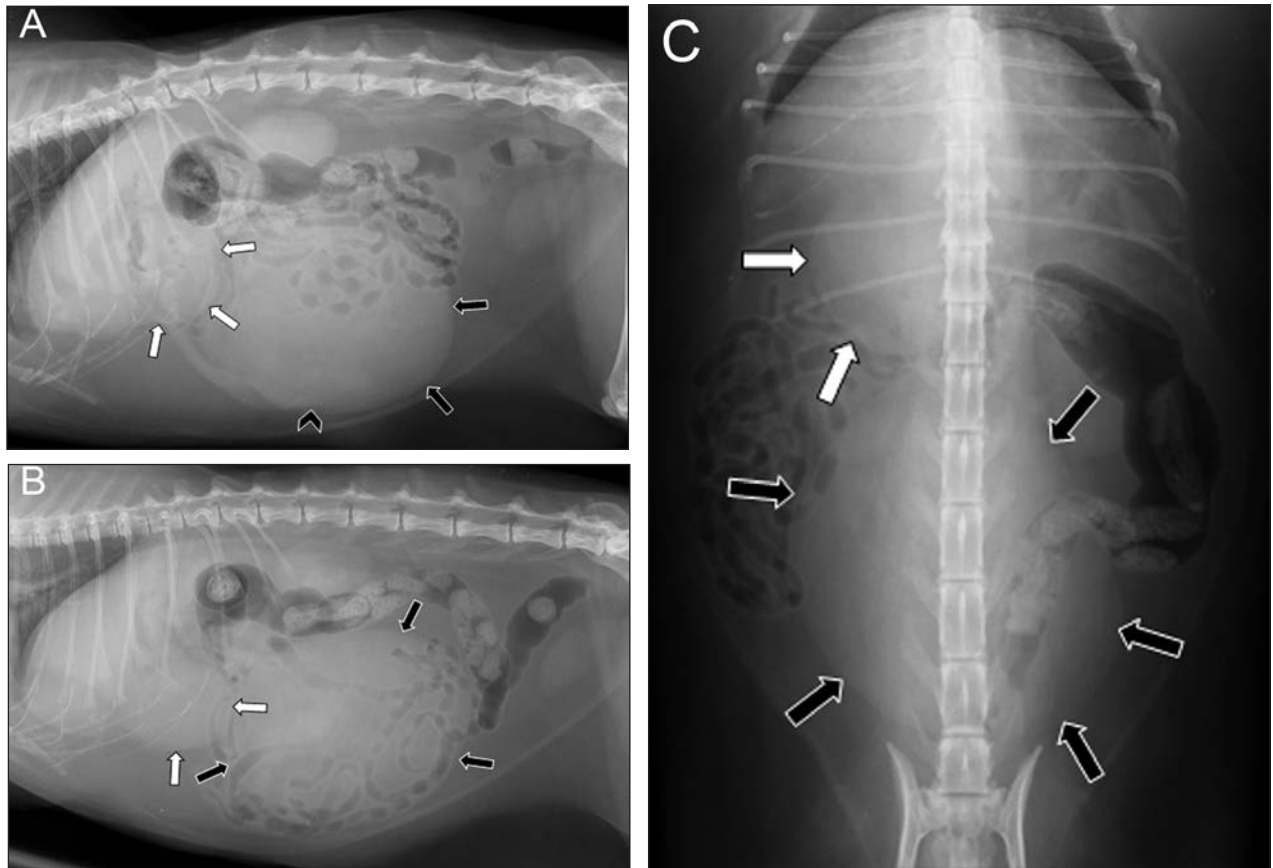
Same radiographic images as in Figure 1. There is a large midabdominal mass (black arrows). The border of the mass effaces with the tail of the spleen (black arrowhead). A mass on the right side of the liver is also present (white arrows).
